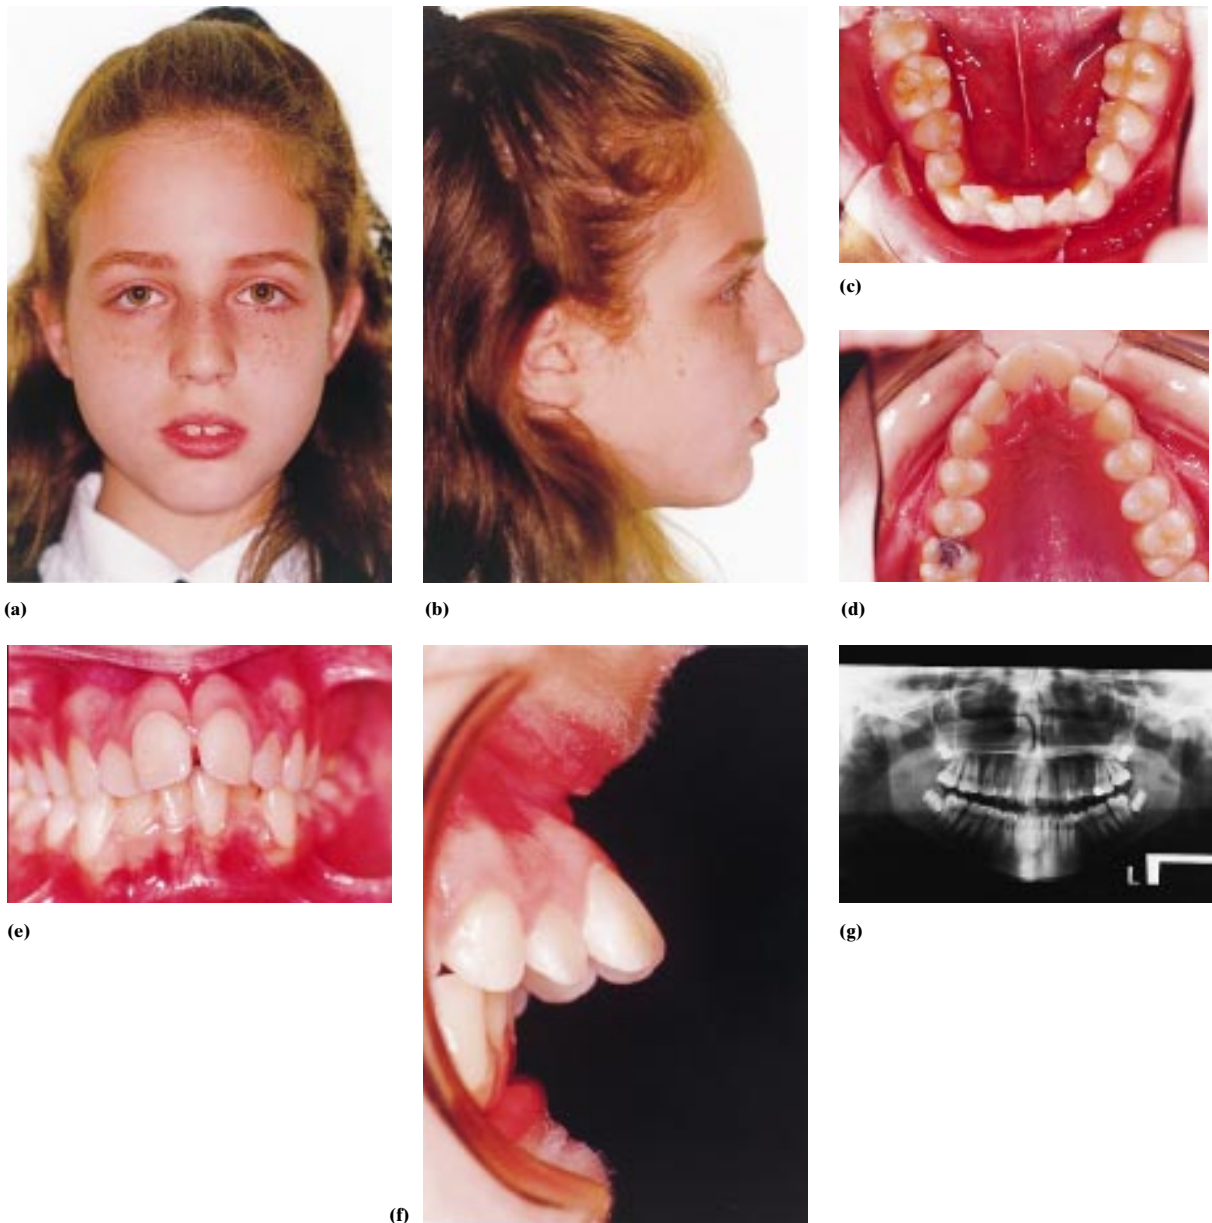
(a–g) Case report 1: pretreatment photographs and orthopantomograph.
